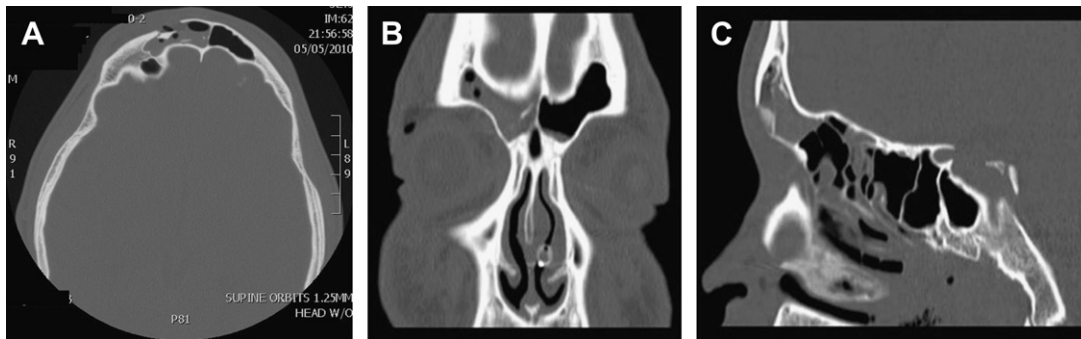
CT scan of patient with fracture of right anterior table of frontal sinus: (A) axial view, (B) coronal view, and (C) sagittal view.
